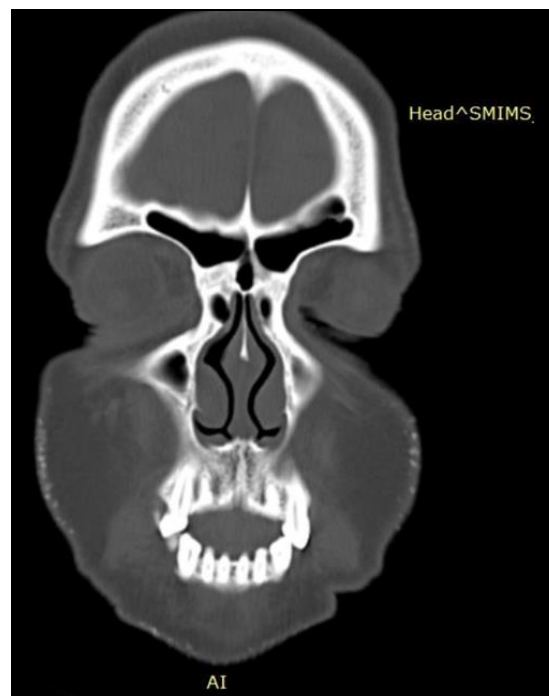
coronal section of CT PNS shows bilateral agger nasi cell.
